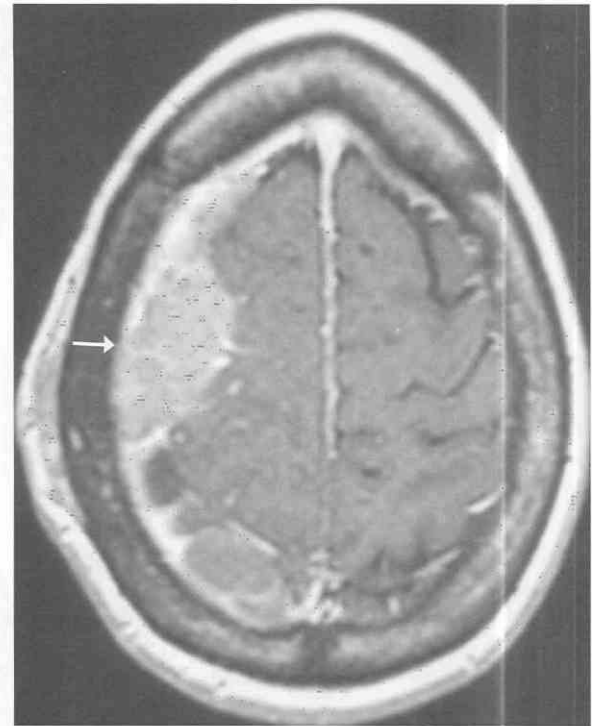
Diffuse pachymeningeal and calvarial metastasis from carcinoma of the breast. Axial T1-weighted postgadolinium MR image demonstrates diffuse nodular and bandlike contrast enhanced thickening of the dura over the high right frontoparietal convexity. The process extends into the falx and across the midline into the high left frontal convexity dura. Several ovoid and plaquelike masses in the right frontoparietal convexity represent outcroppings of dural metastasis (arrow) and compress the underlying frontal and parietal lobes with resultant effacement of the sulci. Note the loss of normal fatty marrow signal in the diploë of the overlying right parietal bone, indicating the presence of calvarial tumor involvement. Immediately posterior and lateral to the arrow is a focal plaque of tumor extension into the subgaleal space, with elevation of the overlying subcutaneous fat of the scalp.
